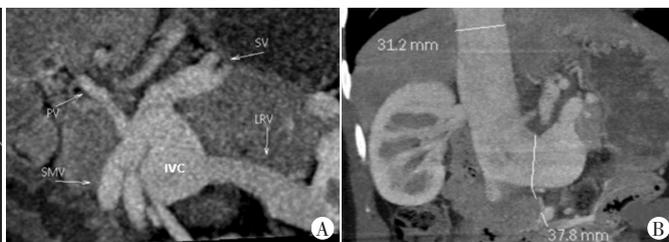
Abernethy 畸形合并肺动脉高压增强 CT 图(PV: 门静脉; IVC: 下腔静脉; SV: 脾静脉; SMV: 肠系膜上静脉; LRV: 左肾静脉)
